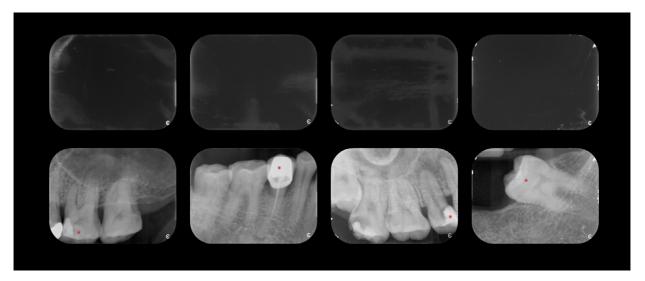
Sample images with intermediate discard proportions. The top row of images shows the artifacts as they would appear if the photostimulable phosphor (PSP) plates were blank exposures, whereas the bottom row represents the corresponding artifacts digitally superimposed over a dental radiograph. The discard proportions for the following PSP plates were (*from left to right*): 30%, 51%, 56%, and 66%.
